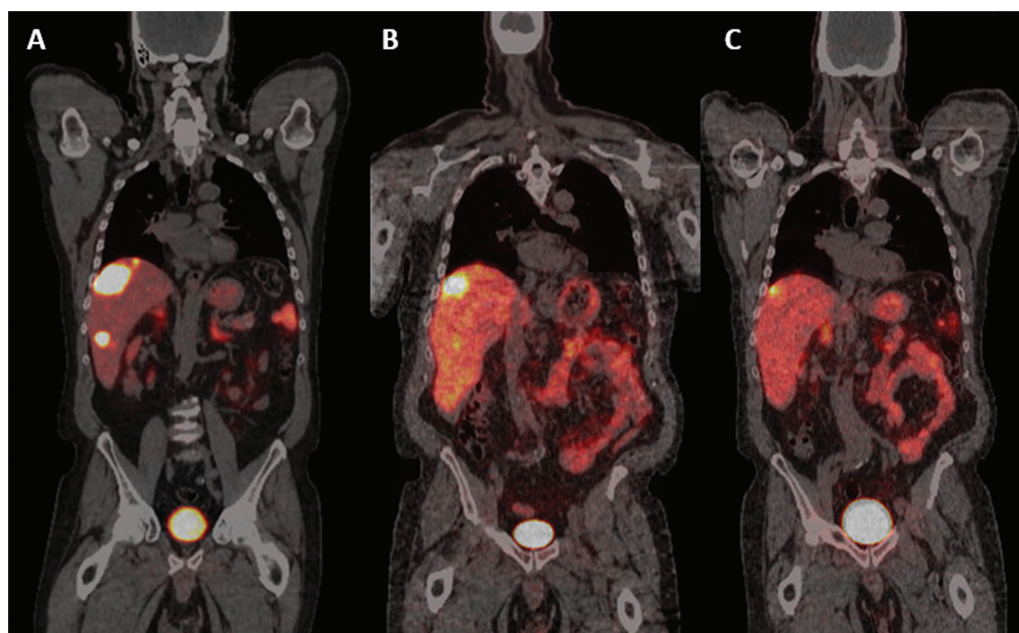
⁶⁸Ga-Dotatate PET/CT of the patient: (A) before, (B) 1 month after, and (C) 5 months after PRRT rechallenge.
